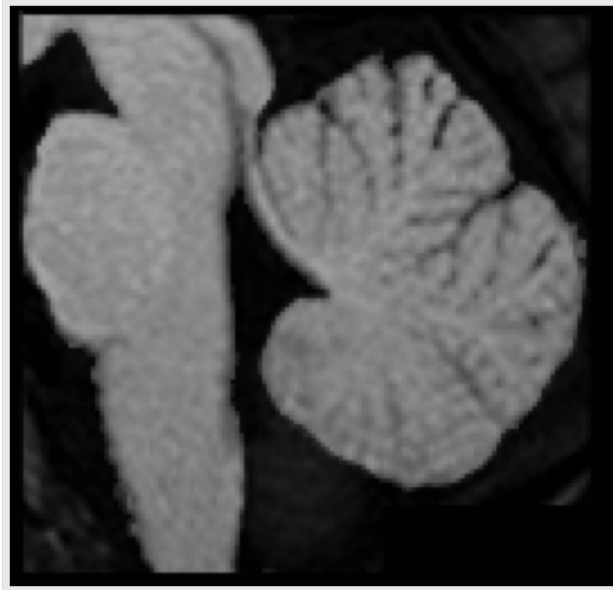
Sagittal MRI image of the brainstem and cerebellar hemisphere. The primary fissure is clearly visible as indicated by the arrow. Image reproduced with permission from Greg Allen, Ph.D.
